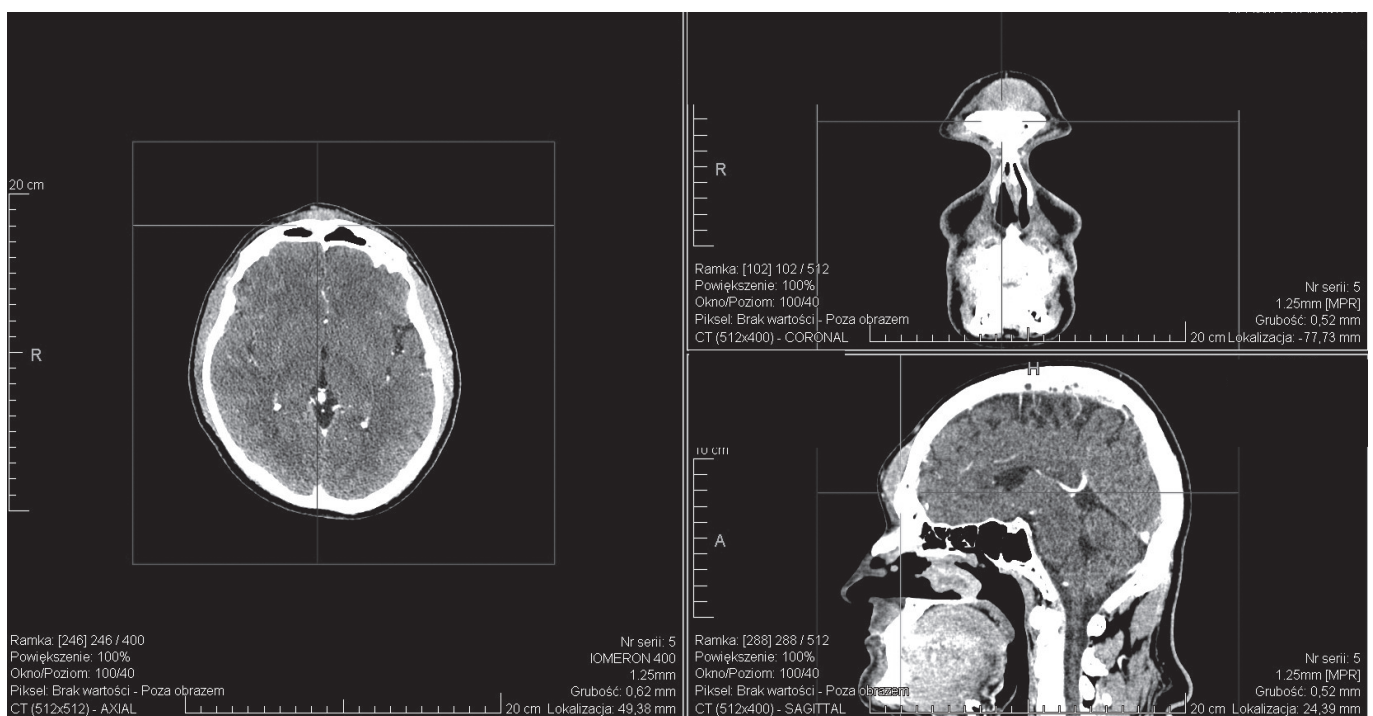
Contrast-enhanced CT of the paranasal sinuses on admission
